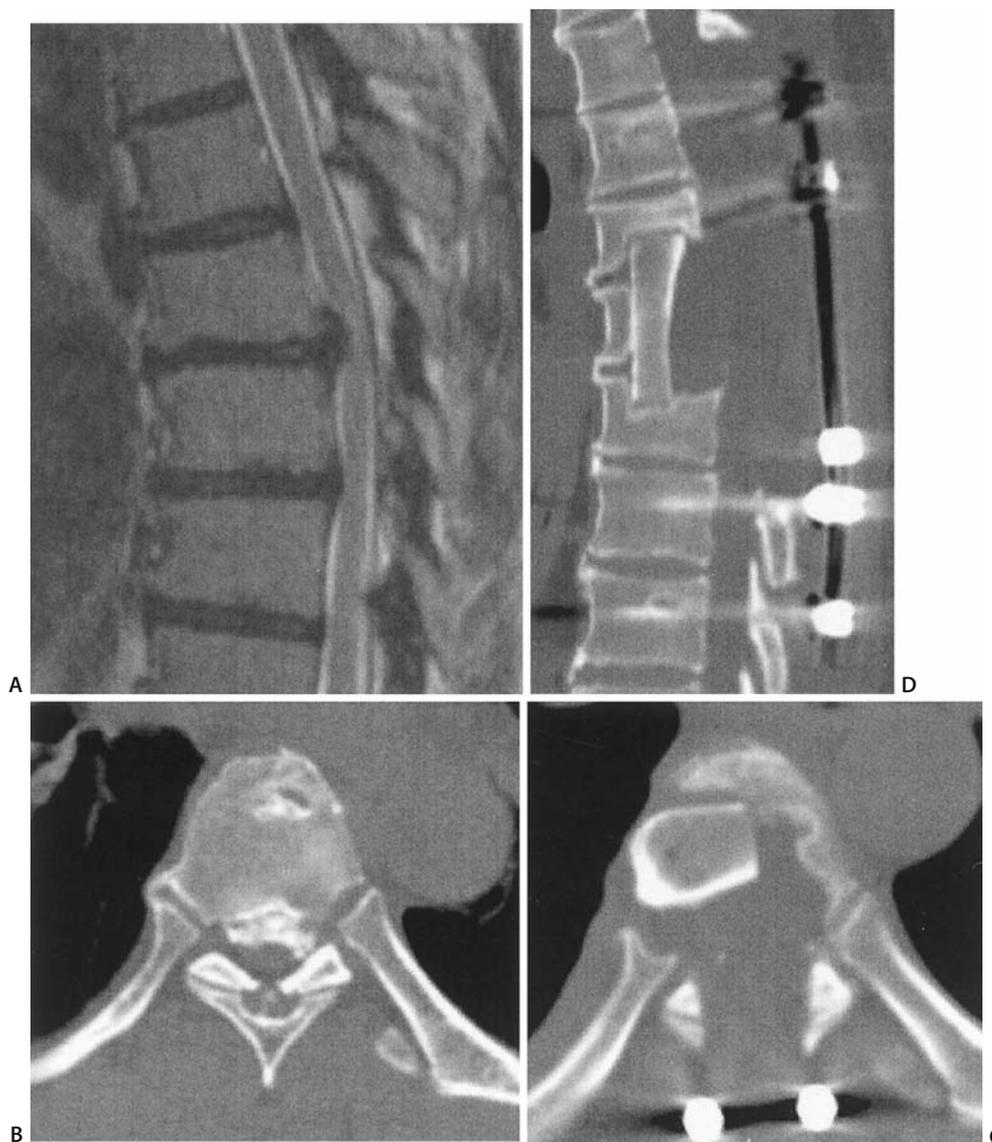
Preoperative and postoperative magnetic resonance imaging (MRI) and CT of case 4. A Preoperative MRI shows beak-type OPLL at T6-T7. B Preoperative CT at T6-T7. C, D
